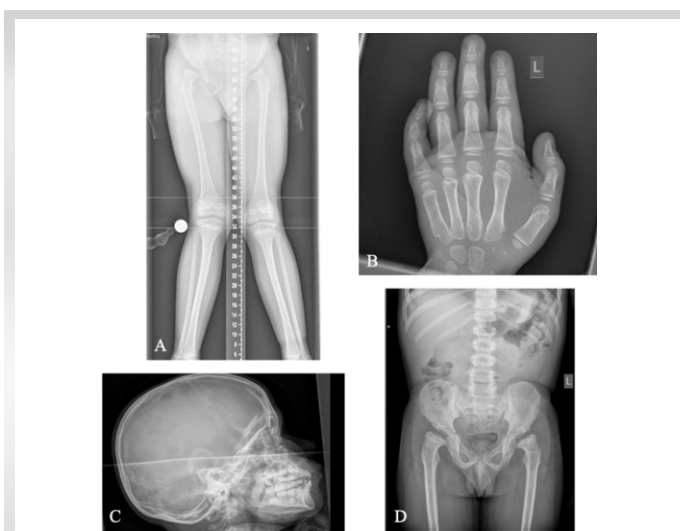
Radiographic features of Morquio syndrome (A-F) A: Coxa valga. Constricted iliac wings, steeply oblique acetabular roofs with absence of the ossified femoral heads. Genu valgus. B: Proximal pointing of the second through fifth metacarpals. C: Mildly dolichocephalic skull (longer than wide). D: Coxa valga. Constricted iliac wings, steeply oblique acetabular roofs with small fragmented proximal femoral epiphyses, irregularity and flaring of the metaphyses.
